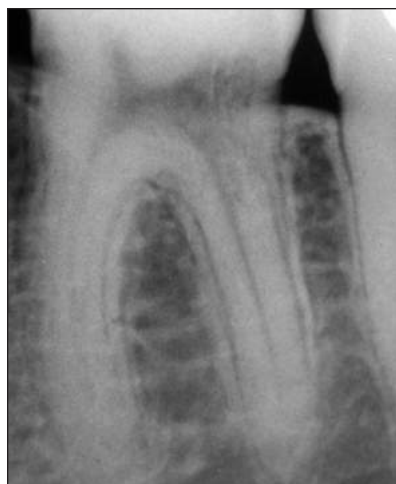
Extracanal invasive resorption in the distal of a mandibular molar. A radiograph taken 2 years prior to this radiograph showed no evidence of resorption.
